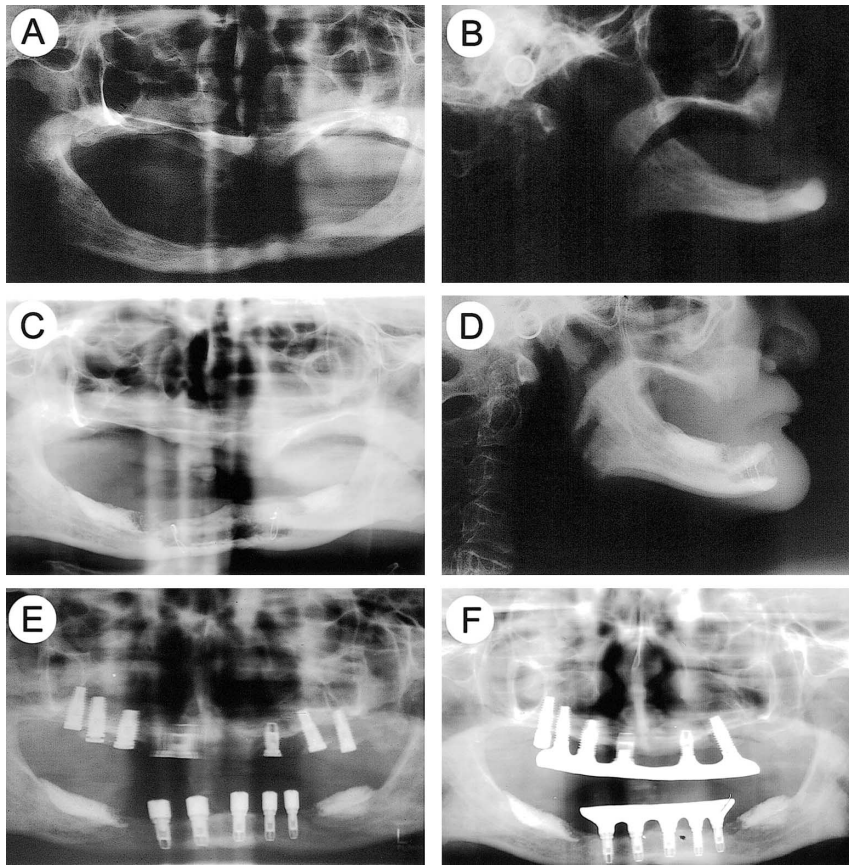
Radiographic examination. (a) The preoperative panoramic film showing the floor of the maxillary sinus close to the ridge crest and a pencil-thin atrophic ridge in the mandible. (b) Preoperative lateral cephalogram showing the severe atrophic ridge with a skeletal class III jaw relation. (c) The postoperative panoramic film showing the augmented sinus and ridge in the maxilla and the reconstructed ridge in the mandible. (d) The postoperative jaw relation was improved by this reconstruction. (e) Five fixtures securely anchoring in the mandible after the second-stage operation. The third implant fixture in the left maxilla seen with significant bone loss at the second stage operation was removed afterward. (f) Panoramic radiograph at the 5-year follow-up showing the stability of reconstruction. The milled bar supported by 5 implant fixtures in each jaw is functioning well.
